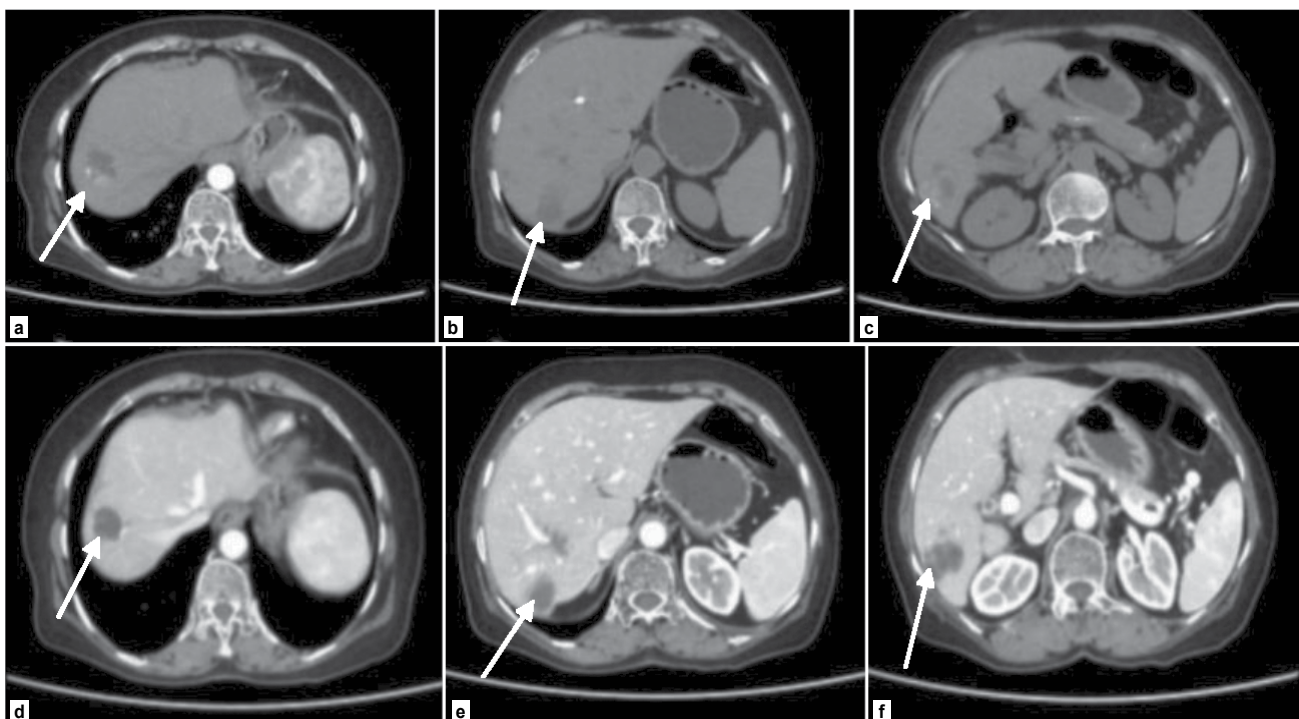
(a-f). CT images of liver showing multiple peripherally enhancing lobulated lesions in the right lobe of liver. Few lesions in the subcapsular region can be seen.
